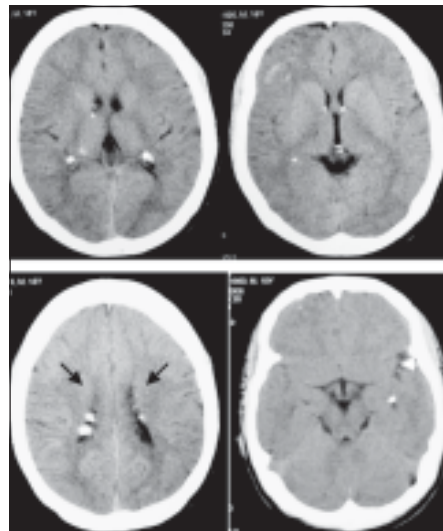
CT scan of head showing subependymal (black arrows) & subcortical (white arrow) calcified tubers.
